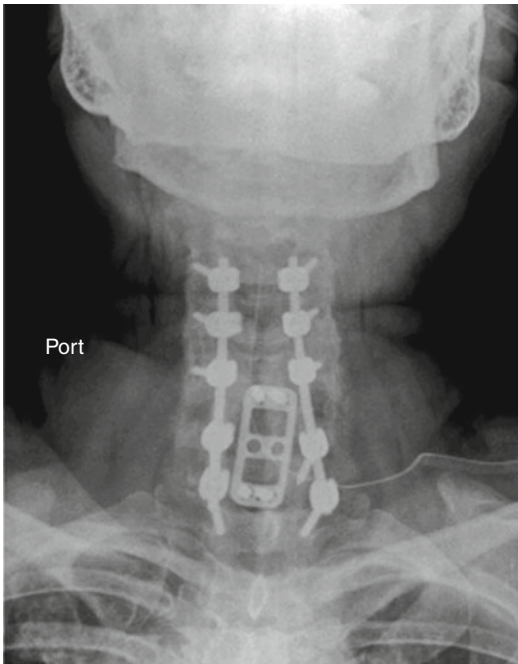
AP radiograph demonstrating a C3–T1 posterior construct with lateral mass screws from C3 to C5 and pedicle screws at C7 and T1. A C5–7 anterior plate was present from a prior operation
